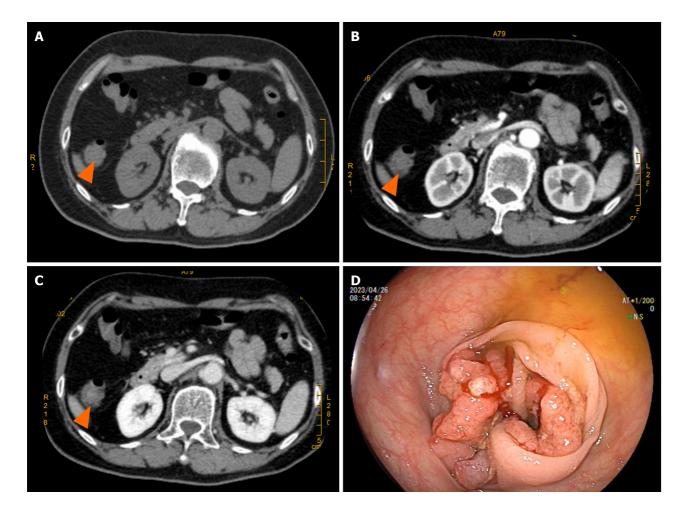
Colonoscopy and enhanced total abdominal computed tomography. A-C: Computed tomography (CT) shows that the colon cancer near the hepatic flexure of the transverse colon invaded the serosal layer, with a maximum invasion depth of approximately 2 cm, with small mesenteric lymph node metastasis (orange triangles) to be ruled out; CT plain scan (A), CT enhanced scan (B), and CT venous phase of the mass (C), respectively; D: Colonoscopy shows an irregular mass with a diameter of > 2 cm located 70 cm from the anus.
